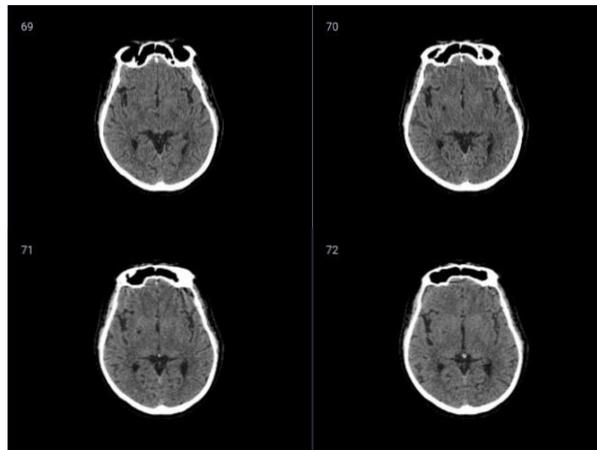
Non-contrast head CT-Scan, axial view
